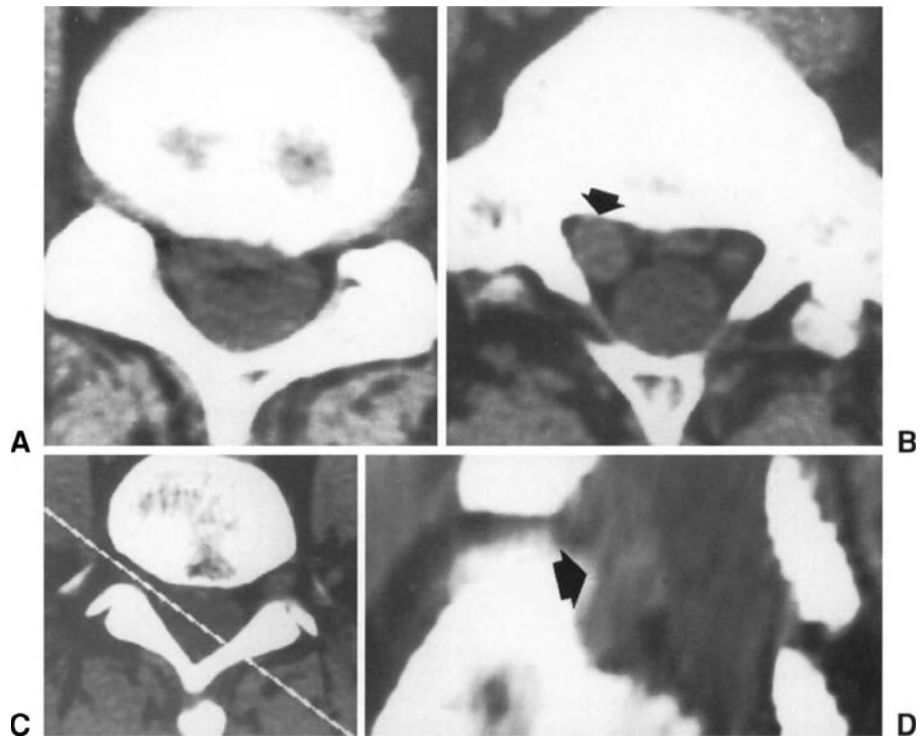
Disc fragment migrated caudally to the L5-S1 disc with a very similar density to that of the nervous structures. (A) Axial CT scan at L5-S1 level. (B) Axial CT scan at the level of the proximal portion of the sacrum; on the right, a low density structure (arrow) is visible, which might be due to anomalous nerve roots or a disc herniation. (C) and (D) Parasagittal reconstruction showing the herniation migrated caudally (arrow).
